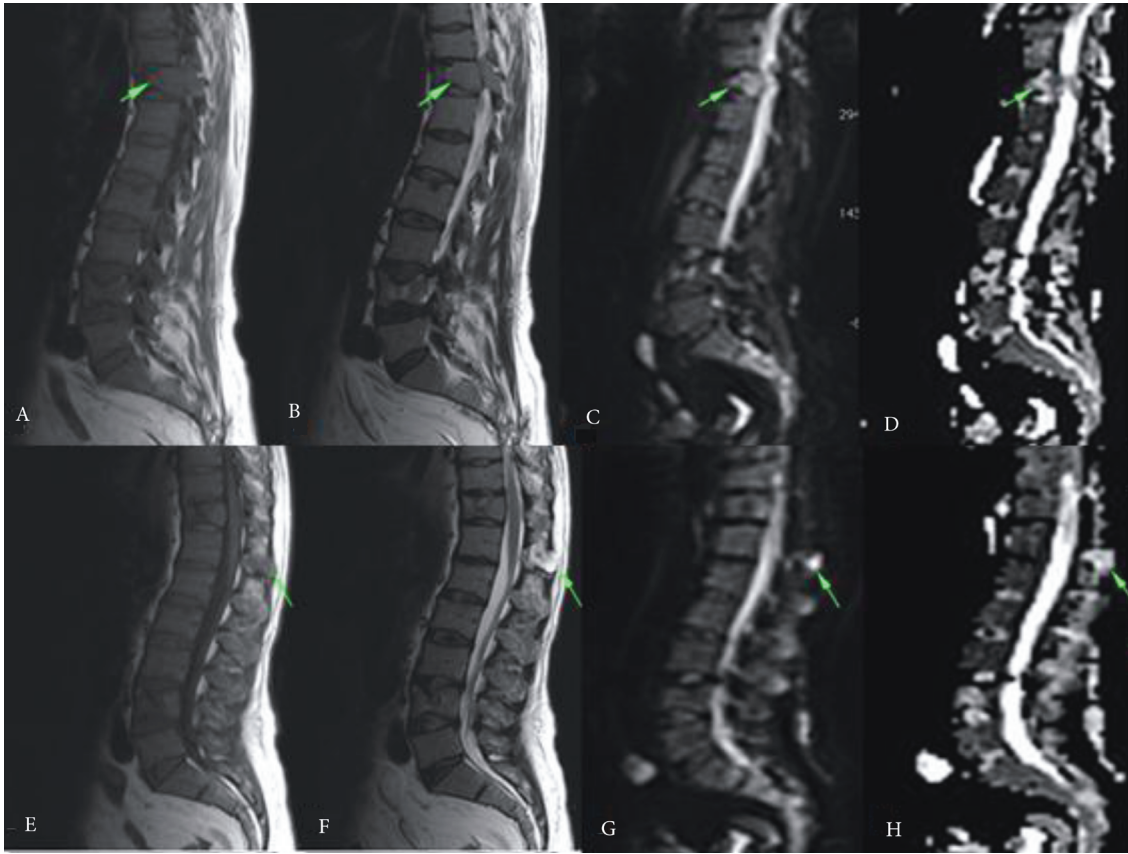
A–H. Active lesions at the T11 vertebra, and lesions that responded to treatment at the processus spinosus of the T12 vertebra of a 58-year-old patient being followed-up for multiple myeloma. The T1-weighted axial MR image (A) and T2-weighted axial MR image (B) show hypointensity in the round lesion with smooth contours at the T11 vertebra (arrow). DWI (C) shows hyperintensity in the lesions (arrow). The ADC map (D) shows hypointensities in these lesions due to restricted diffusion (arrow). The mean ADC value is $0.83 \times 10^{-3} \text{ mm}^2/\text{s}$ at the ADC measurement of the lesion and supports the involvement of multiple myeloma. There is a hypointense lesion at the processus spinosus of the T12 vertebra. The T1-weighted axial MR image (E) shows hypointensity in the round lesion (arrow). The T2-weighted axial MR image (F) shows hyperintensity in the lesion (arrow). DWI (G) and ADC maps (H) show hyperintensities in these lesions due to increased diffusion (arrow). DWI (G) shows hyperintensity in the lesion (arrow) due to T2 brightness. The mean ADC value is $2.41 \times 10^{-3} \text{ mm}^2/\text{s}$ at the ADC measurement of the lesion and supports response to treatment.
